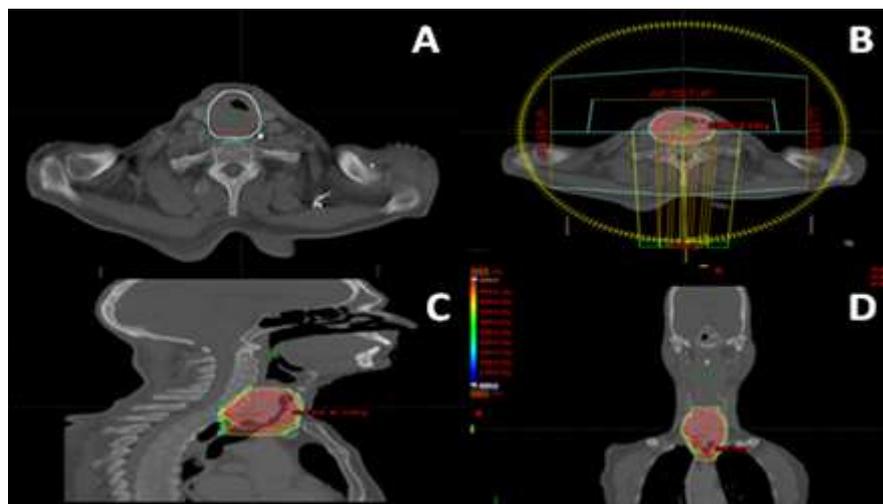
A) Axial section of planning CT scan showing the Gross tumor volume (GTV) (red) and clinical target volume (CTV) (cyan), B) Tracheal tumor being treated by Arc therapy C) Sagittal dose distribution D) Coronal dose distribution of the radiation treatment plan [Pseudo-colouring shows the high dose (shown in red) and low doses (shown in green and blue) regions]
